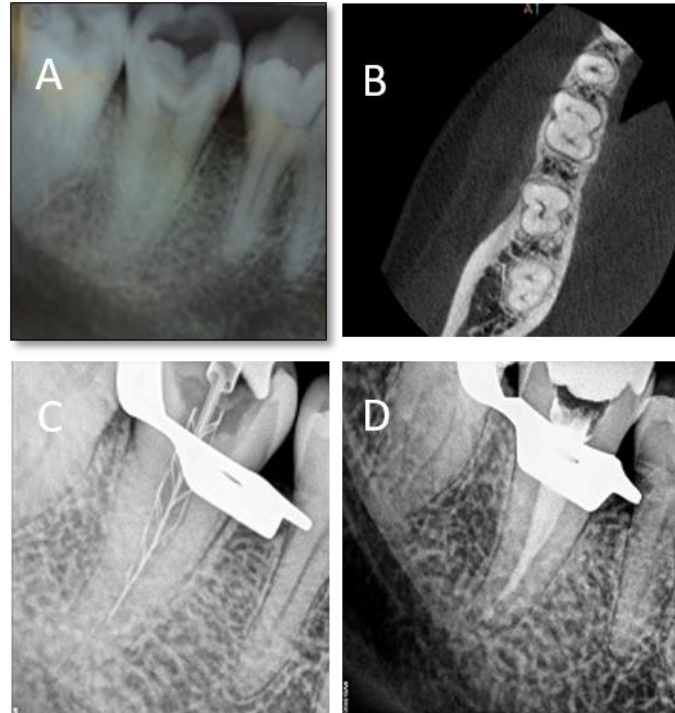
(A)Pre-operative IOPA with 47 (B) Pre-operative CBCT view (axial section) showing C-shaped canal anatomy(C) cleaning and shaping done using SAF system (D) Root canal obturation using Ultrafil 3D injectable gutta-percha along with AH-plus root canal sealer
